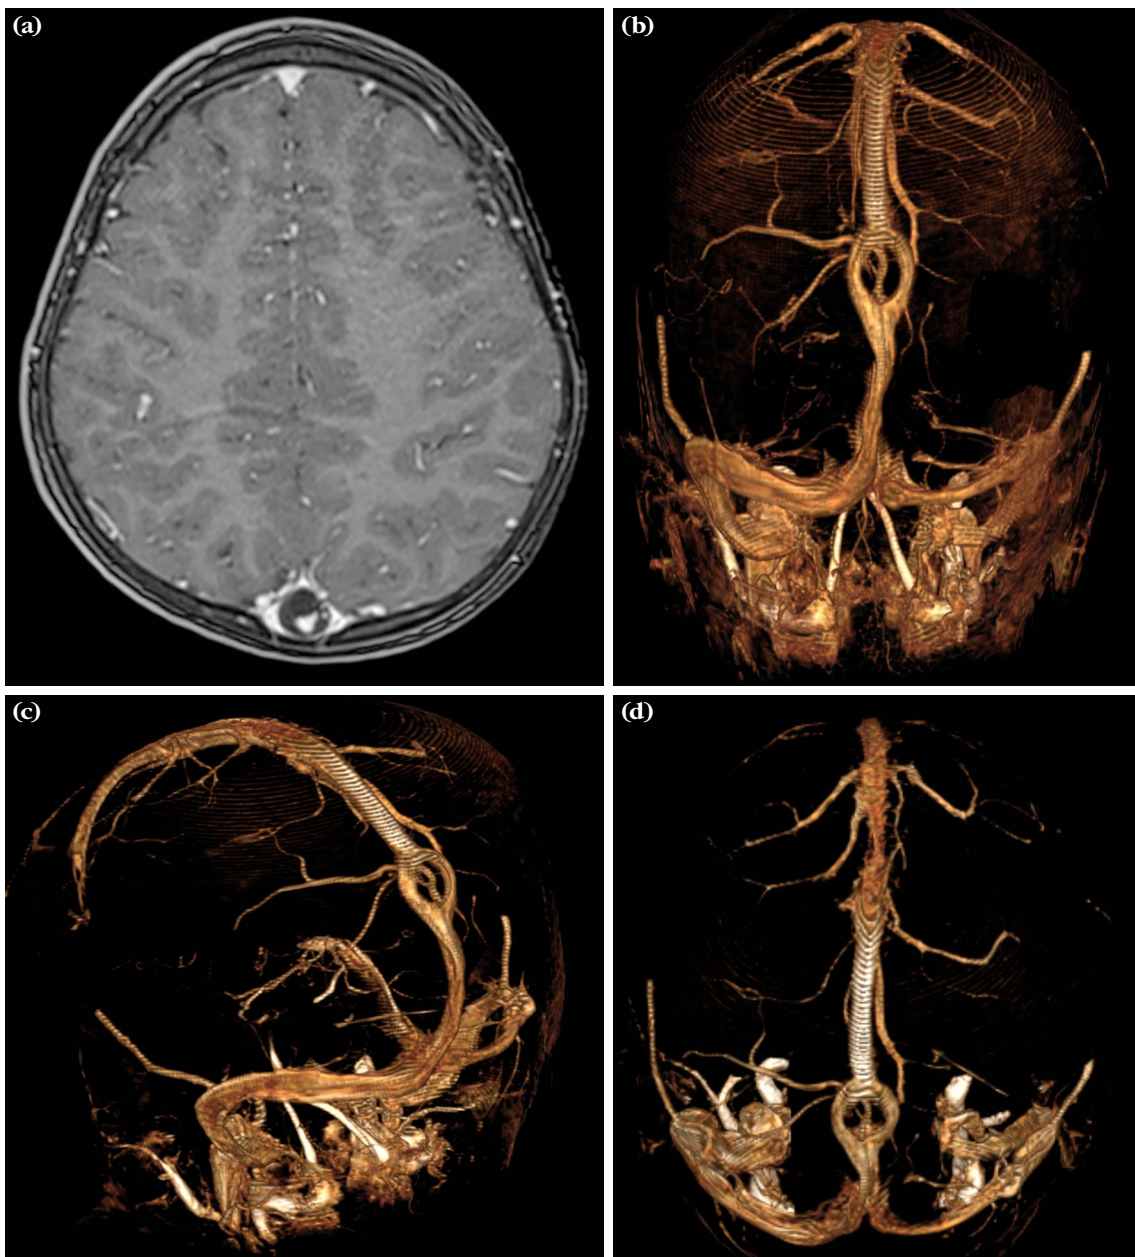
(a) Patient's axial magnetic resonance imaging demonstrating an abnormal sagittal sinus. Magnetic resonance images of the patient with an abnormal sagittal sinus on (b) back, (c) oblique, and (d) top views.
